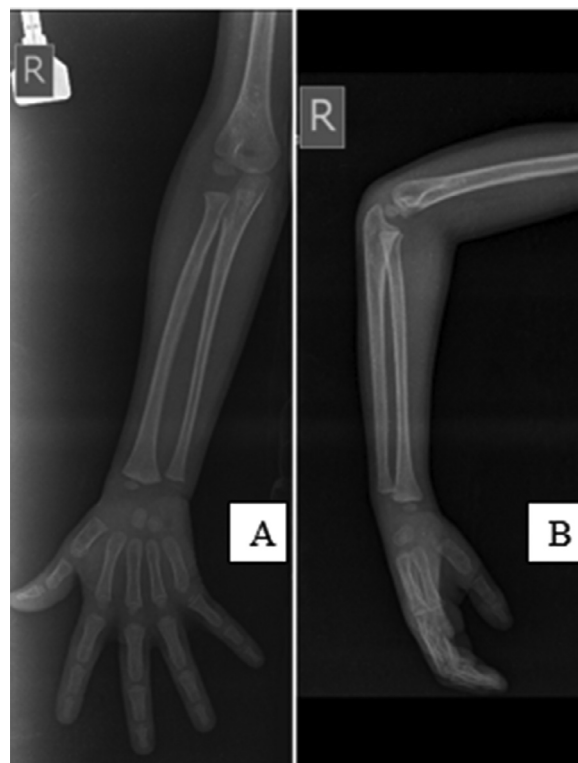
(A) AP and (B) lateral radiographs showing normal bones of the right elbow, radius and ulna, wrist and hand.
